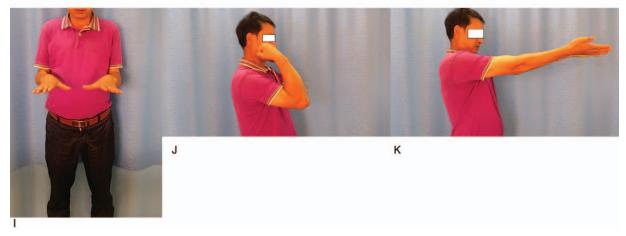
Internal fixation of a comminuted radial head fracture with 2 mother-child screws is shown. (A-C) Preoperative radiographs demonstrating a comminuted Mason type-II fracture. (D-E) Intraoperative photographs showing the radial head fracture, consisting of 2 fragments. (F-G) Postoperative radiographs showing that the fragments were reduced and fixed with 2 mother-child screws. (H-K) Elbow range of motion at 6 months of follow-up.
